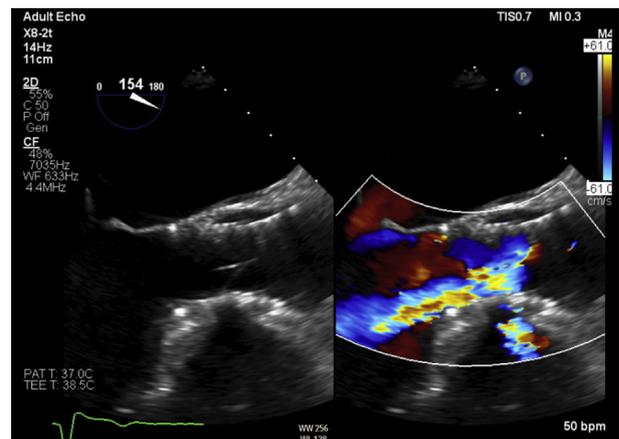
Transesophageal echocardiogram showing transcatheter aortic valve with severe eccentric aortic insufficiency secondary to flail leaflet.
